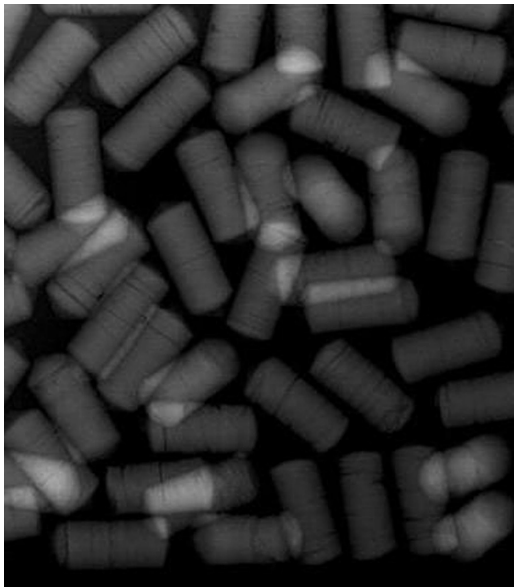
A radiograph of the bag of packets noted in the case. Taking a radiograph of the isolated packets, if available, may help to demonstrate their radiographic appearance and assist with locating them on a body packer's abdominal radiograph.
